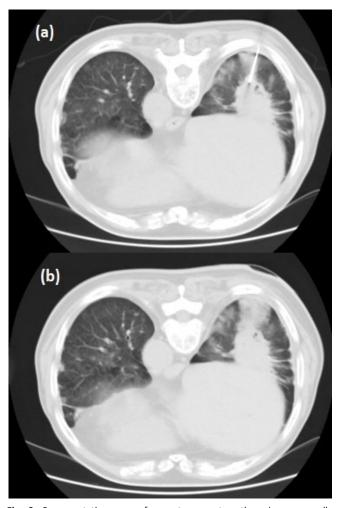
Representative case of percutaneous transthoracic core needle biopsy in a Relapsed NSCLC patient. Axial CT image (lung window) (5 mm section thickness) shows a mass in the right middle lobe; (a): Surface Markers; (b): Coaxial needle approach; (c): Advancement to lesion-Repeat CT scan obtained after needle insertion ensures that the needle tip (arrow) is located within the target mass
